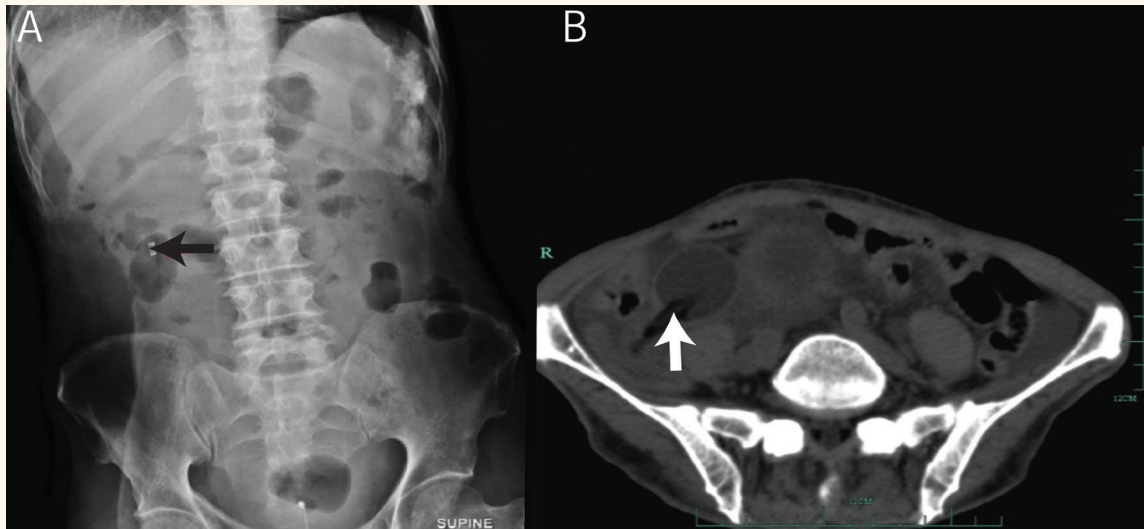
A & B: Plain radiograph of the abdomen showing (A) the Foley catheter tip in the right upper quadrant (black arrow) and (B) axial image of computed tomography scan showing Foley catheter with the inflated balloon positioned at the ileocecal valve (white arrow).
